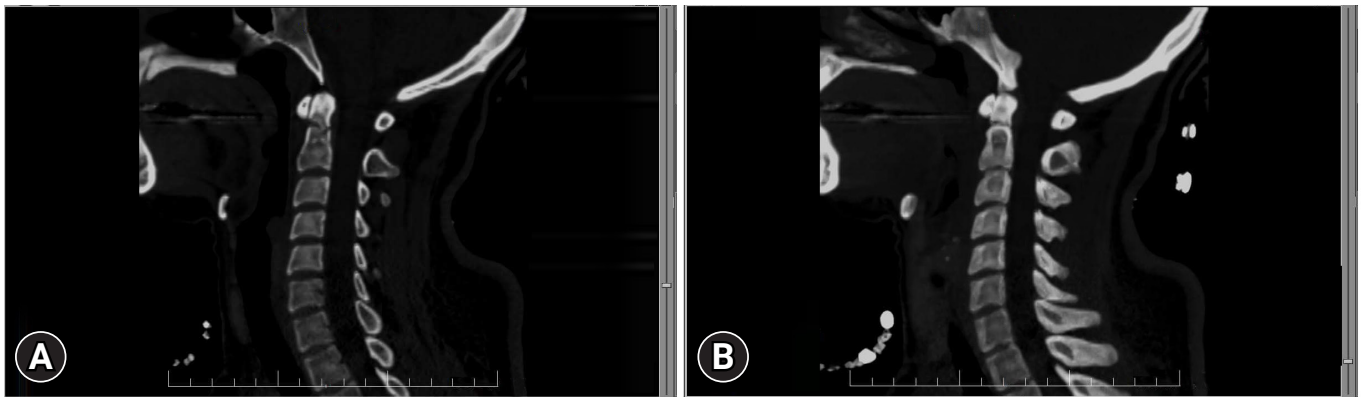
A sagittal reformatted computed tomography scan of the cervical spine. (A, B) The images reveal the previously described complete, irregular fracture at the base of the odontoid process (C2).
